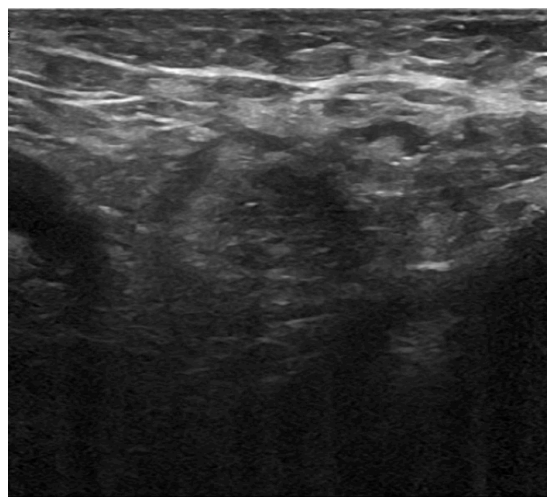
Sonography revealing mammary tissue in axilla
